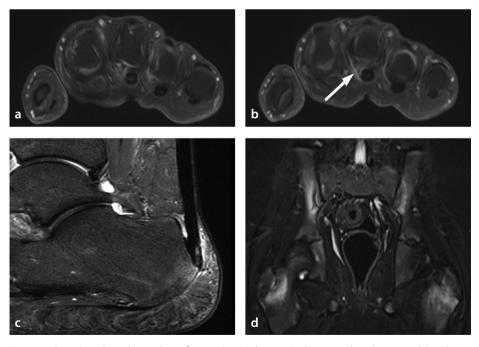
Synovioentheseal complex inflammation in rheumatic diseases other than spondyloarthritis. (a, b) Transverse fat-saturated T1W post-contrast magnetic resonance images (MRI) of a 58-year-old woman with seronegative rheumatoid arthritis show mild second through fourth metacarpophalangeal joint synovitis along with A1 pulley enthesitis of the third finger (b, arrow). (c) Sagittal fat-saturated T2W MR image of a 54-year-old woman with Sjögren syndrome shows Achilles tendon enthesitis characterized by intra- and peritendinous hyperintensity, subcortical bone marrow edema at the entheseal insertion, and retrocalcaneal bursitis. (d) Coronal short tau inversion recovery MR image of a 12-year-old boy with chronic non-bacterial osteomyelitis shows bilateral active on chronic sacroiliitis prominent on iliac sides with characteristic periphyseal osteitis at proximal femurs.
